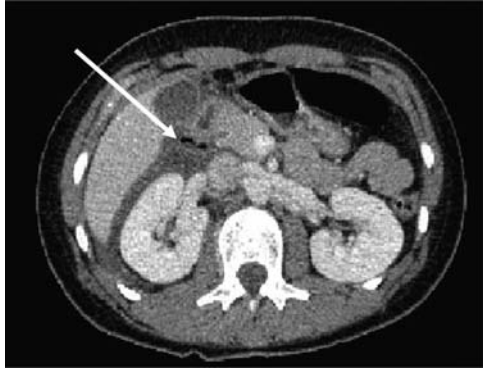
CT of abdomen showing free air in right para-renal space (white arrow).
